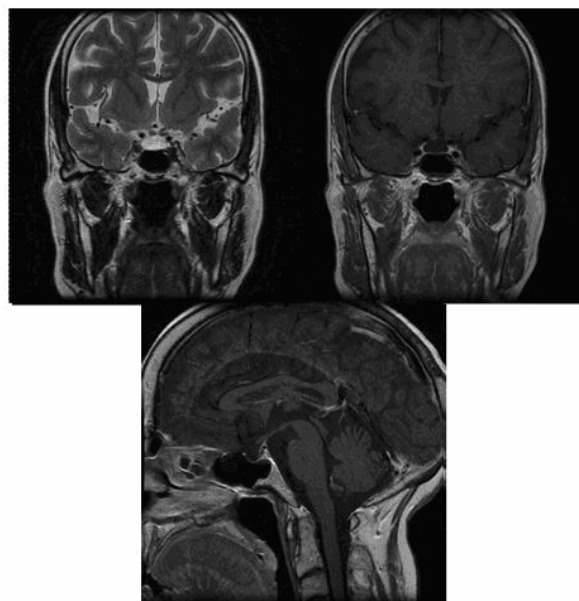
MRI showing an empty sella turcica
